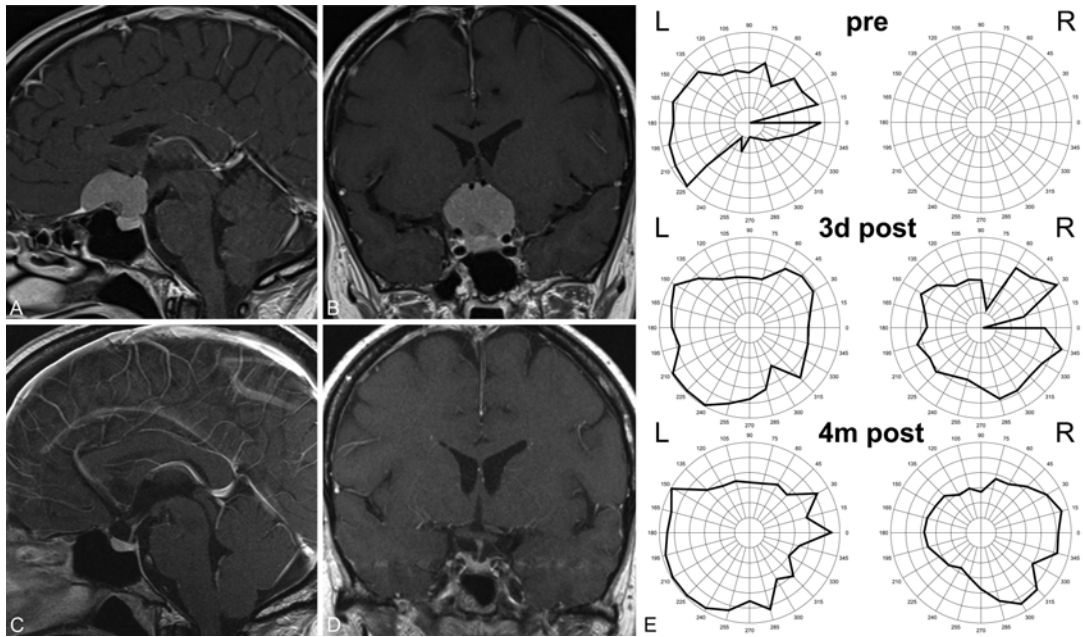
Case 2. Preoperative (A and B) and postoperative (C and D) sagittal (A and C) and coronal (B and D) contrast-enhanced MR images and results of visual field testing (E) obtained in a representative case in which TSM surgery was performed via a frontolateral craniotomy with a skin incision behind the hairline. The improvement of the visual field can be seen from preoperative testing (pre) to testing performed 3 days after surgery (3d post) and 4 months after surgery (4m post).
